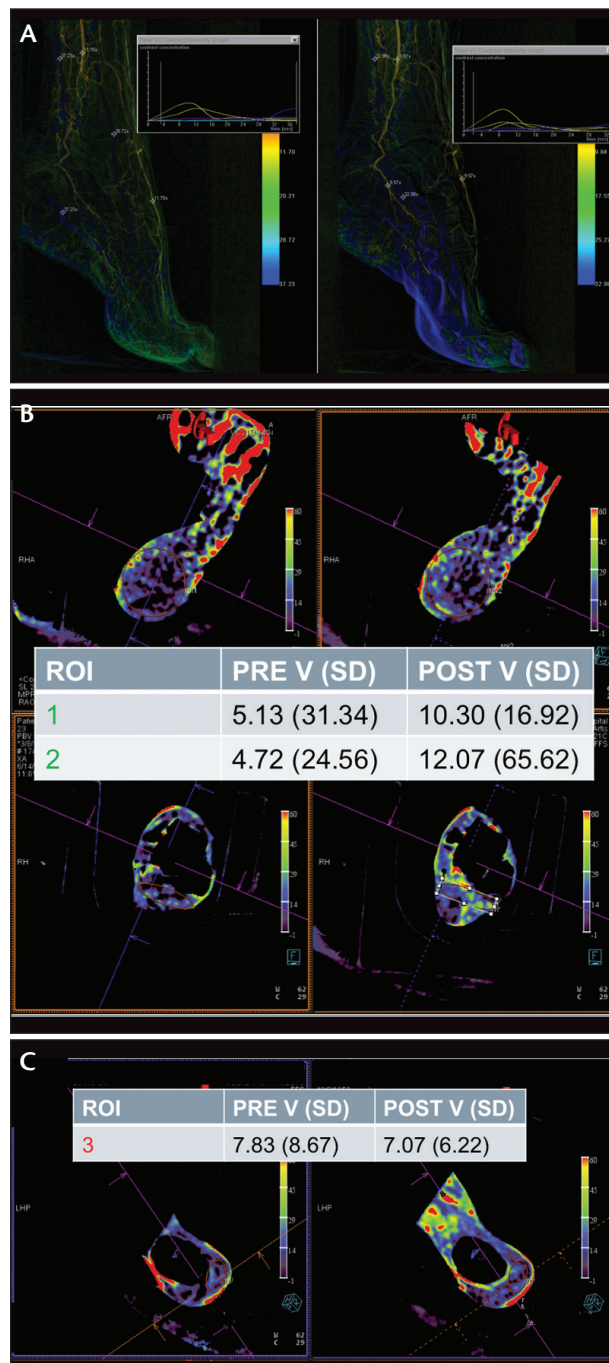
Three-dimensional CT perfusion study of a 68-year-old patient with significant tissue loss overlying the Achilles tendon. Two-dimensional CT perfusion angiography before and after revascularization demonstrated improvement in time to arrival of contrast after treatment (A). Three-dimensional CT perfusion angiography confirmed improved tissue perfusion in several areas of the heel (B). An area over the Achilles tendon did not show improved perfusion. This ulcer had not completely healed by 3 months (C).
